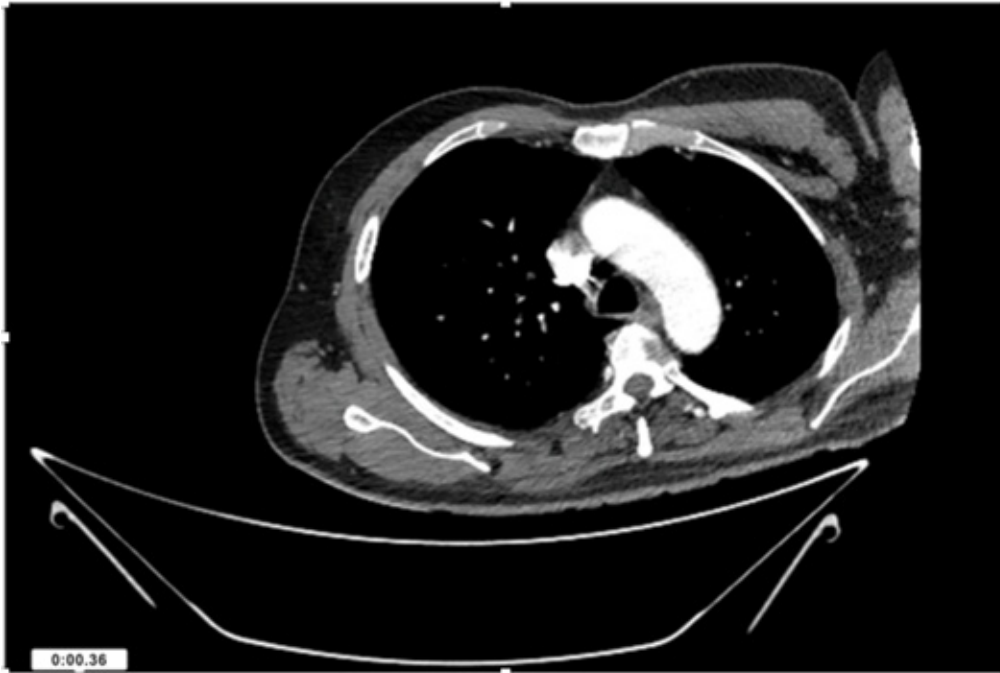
CT Angiogram at thorax showing normal arch of aorta.
